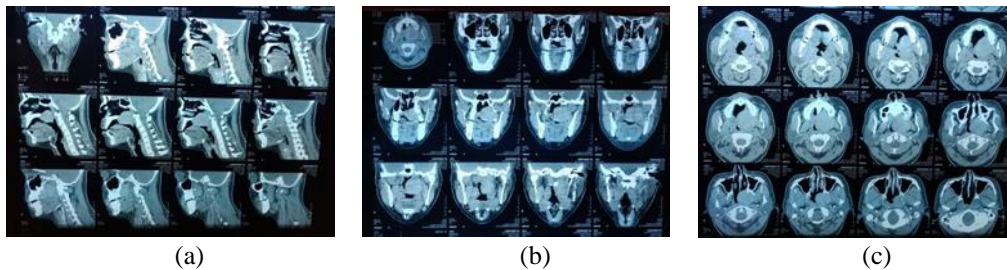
Head and Neck CT scan with Contrast (a) sagittal view, (b) coronal view, (c) axial view
